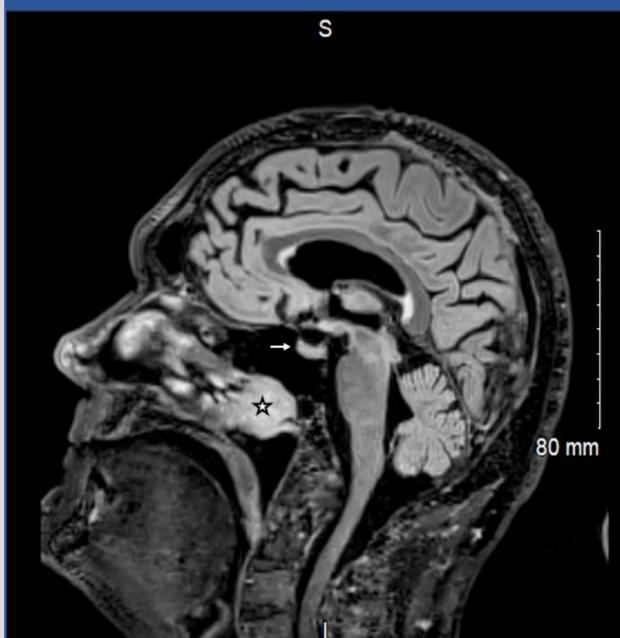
(Left) Sagittal T2 weighted FLAIR MRI. Star denotes the ectopic pituitary adenoma. Arrow indicates normal position of the pituitary gland in the sella. (Middle) Intraoperative view of intact sellar wall. (Right) Dotted circle denotes opened sellar wall and dura without pituitary adenoma.
